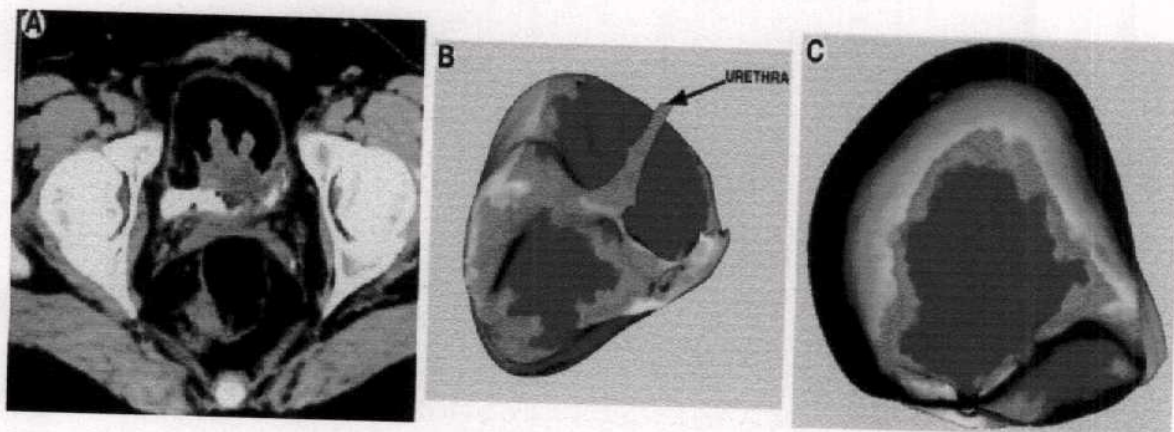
52 year old male with history of bladder cancer. (A) Axial CT image shows subtle thickening of the left bladder wall (arrow). (B) Color mapped virtual endoscopy. Inferior-superior view with catheter and left ureter as landmarks. Green color mapping of the left bladder wall, indicating thickening (Schreyer et al., 2000).
